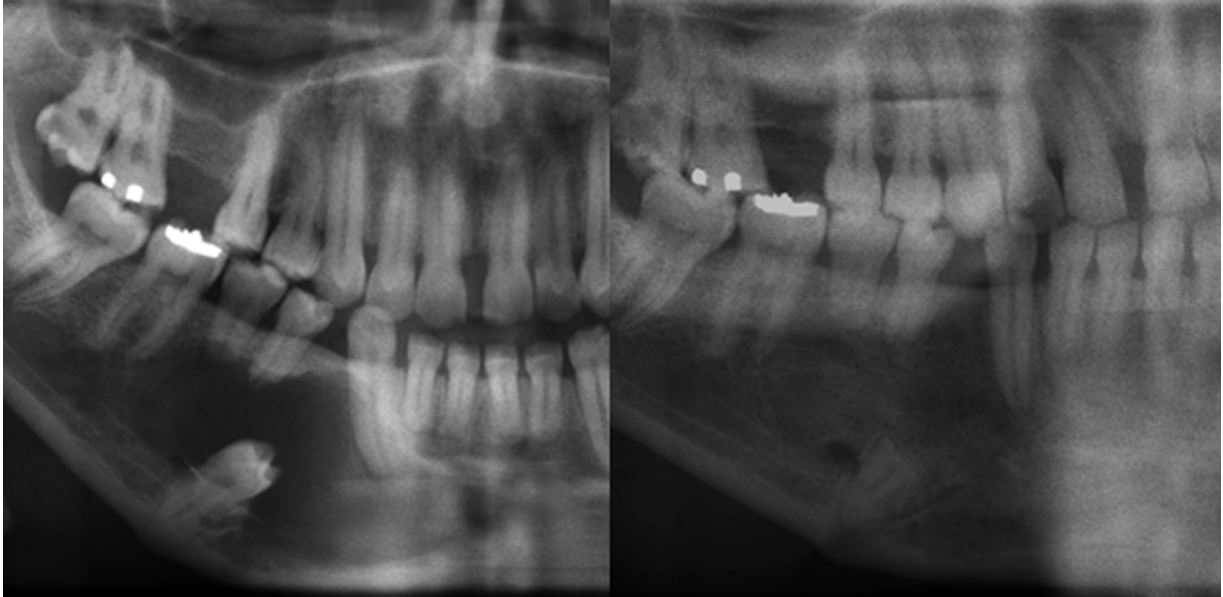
Left side: Preoperative radiograph of LR supernumerary tooth associated with a dentigerous cyst that had been displaced to the lower border of the mandible. The cyst had caused resorption of the roots of LR4 and LR5. Right side: 19-month postoperative radiograph showing bony infill after enucleation of the dentigerous cyst and migration of the LR supernumerary root by about 4 mm. LR4 and LR5 are retained and sound.
